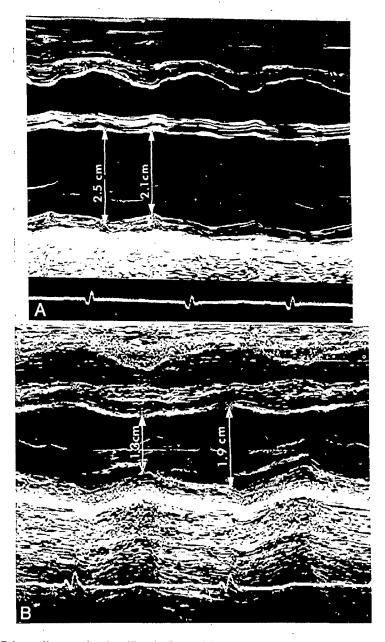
A, Echocardiogram showing dilated left ventricle with markedly decreased shortening fraction of 12%, compared with B, which shows return of left ventricle to normal dimensions and systolic function.
